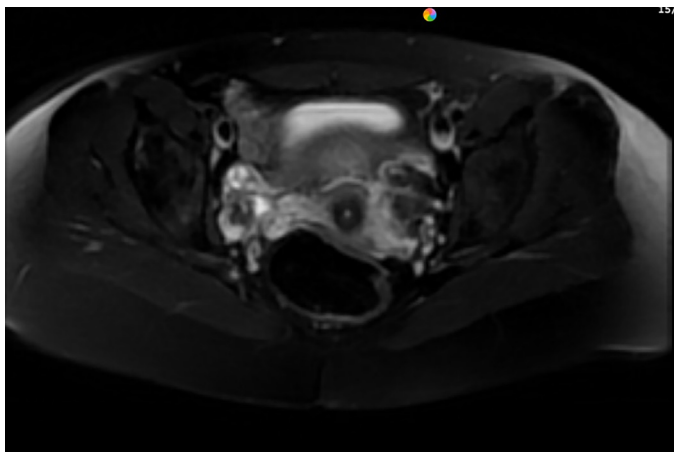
T2-weighted FS MRI showing a tubular structure in the right adnexal area
